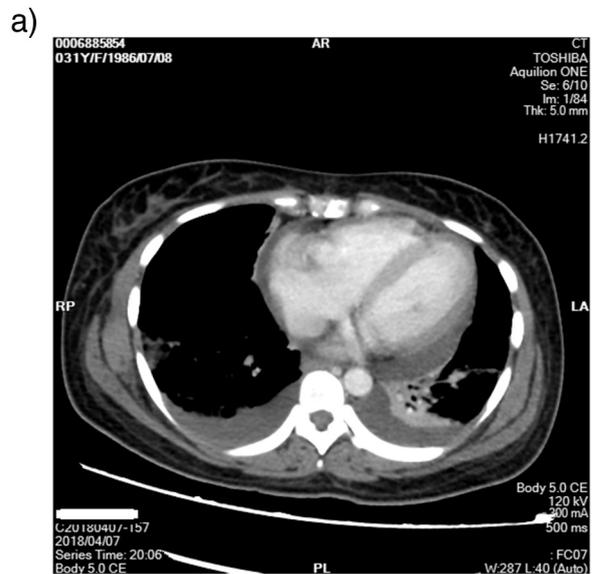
Chest and abdominal CT scan showing bilateral lung infection, bilateral pleural effusion, pericardial effusion, splenomegaly, thickened intestinal walls, enlarged retroperitoneal lymph nodes, and pelvic effusion.
